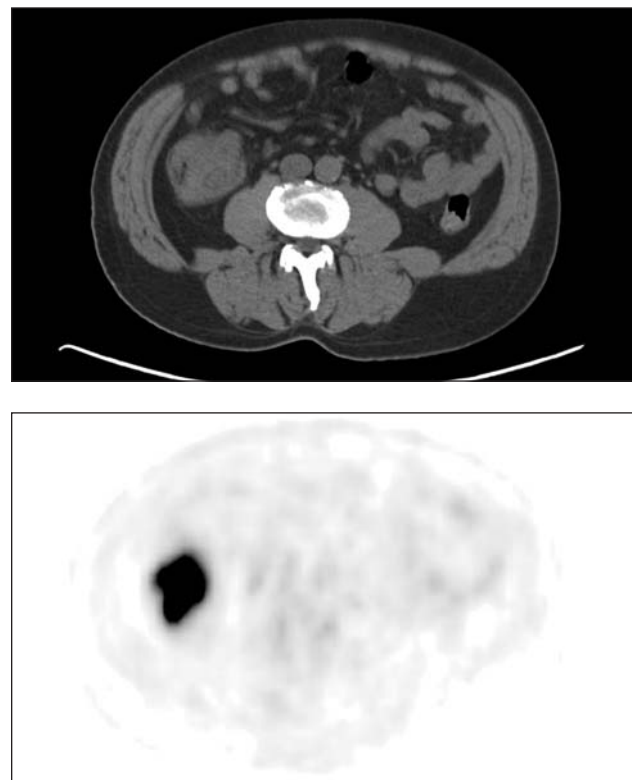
Colon Carcinoma. a) CT image from a PET CT reveals a large mass in the right colon (arrow). b) PET image at same level as 1a reveals marked increase in metabolic activity within the mass.
